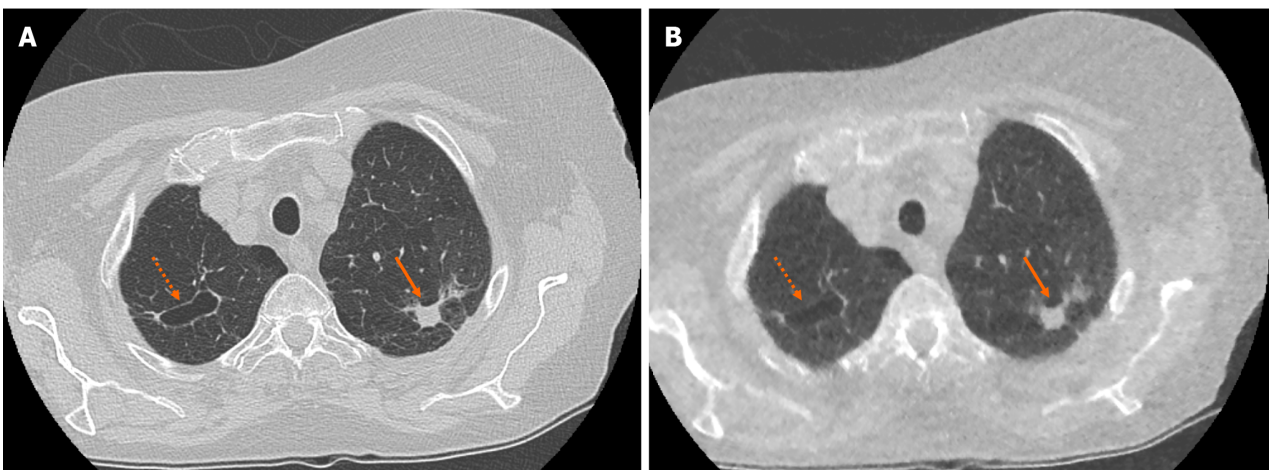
Example of accurate pulmonary nodule characterisation on ultra-low-dose computed tomography chest. A: Selected axial slice of a standard dose computed tomography (CT) chest presented in lung windows with a spiculated solid pulmonary nodule with pleural tethering in the apico-posterior segment of the left upper lobe (solid arrow) and a parenchymal cyst in the apical segment of the right upper lobe (dashed arrow); B: Selected axial slice in the same patient presented in lung windows at the same level highlights the ability of ultra-low-dose CT chest with model-based iterative reconstruction to correctly characterise pulmonary nodule features such as spiculation, tethering and cavitation.
